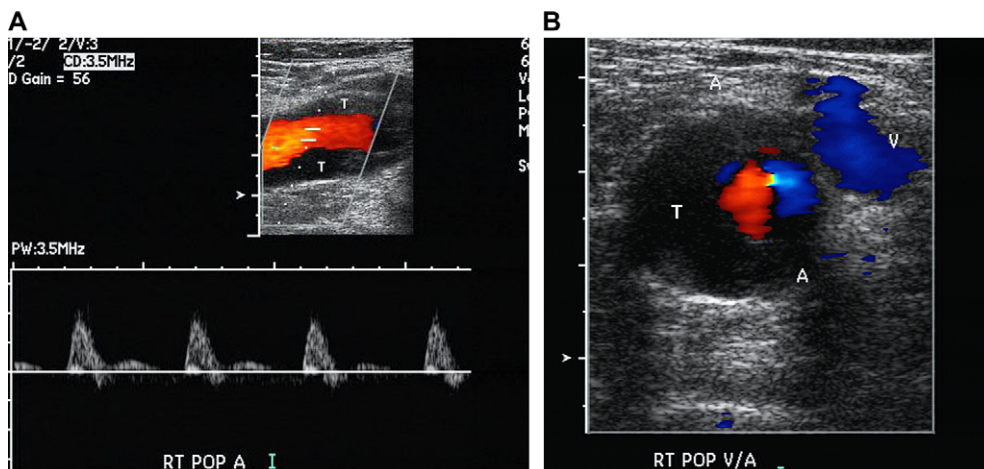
Popliteal artery aneurysm. (A) Sagittal and (B) transverse color Doppler US of a partially thrombosed popliteal artery aneurysm (A) causing pain and calf swelling. Note absence of flow in the thrombosed portion (T).
